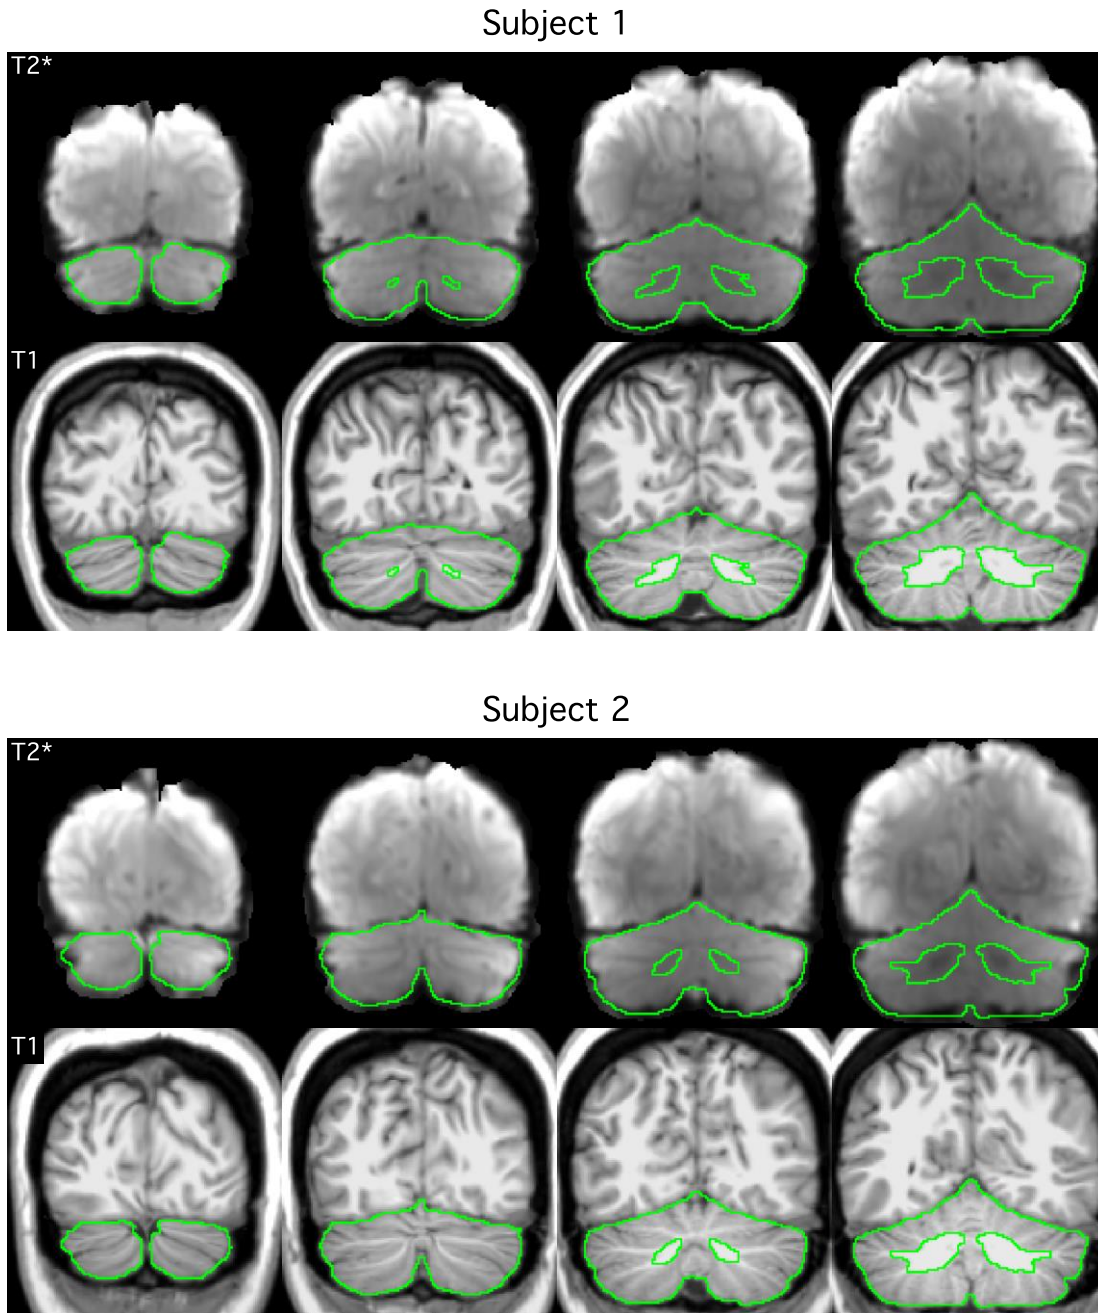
Extracted cerebellar boundaries for subjects 1 and 2 in MNI152 atlas space. The top row of each panel displays the T2 blood oxygenation level-dependent (BOLD) images. The bottom row of each panel shows the T1-weighted images. The green line shows the boundary of the cerebellum mask manually delineated based on each individual subject's T1-weighted image. There is good agreement between the green line and the cerebellum in the T2 images, suggesting good T1-T2 alignment. Imperfections in the BOLD data are also visible, e.g., signal dropout near the green cerebellar boundary.
